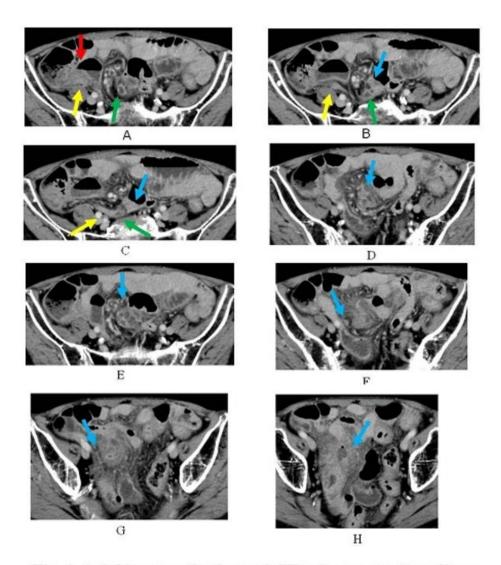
Axial images of enhanced CT using contrast medium depict normal-sized appendix above the psoas muscle (A, B, C yellow arrow) and the swollen appendix in the middle of appendix (C, B, A, green arrow) and the swollen coiled appendix (B-H, blue arrow).
